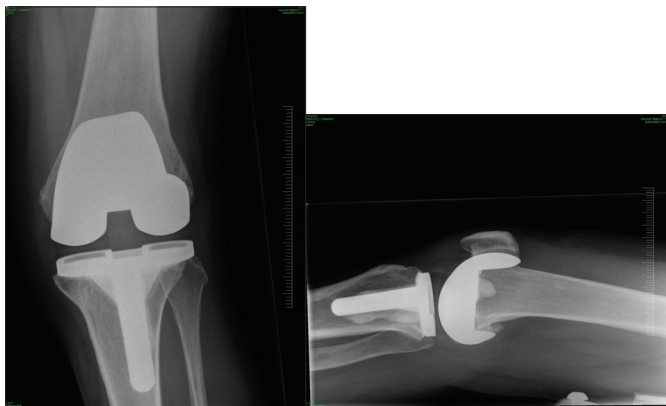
Postoperative Anteroposterior and Lateral Radiograph.
